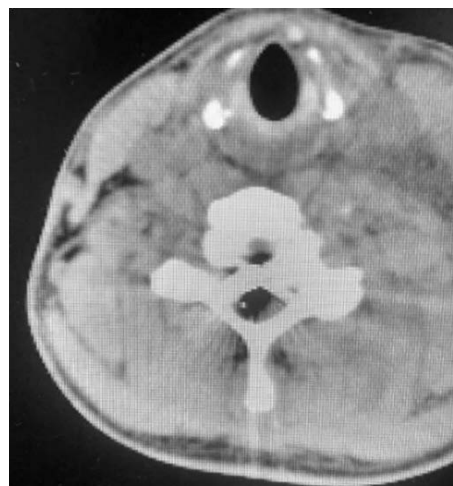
Cervical spine CT scan showing Pneumorrhachis at the height of C7
